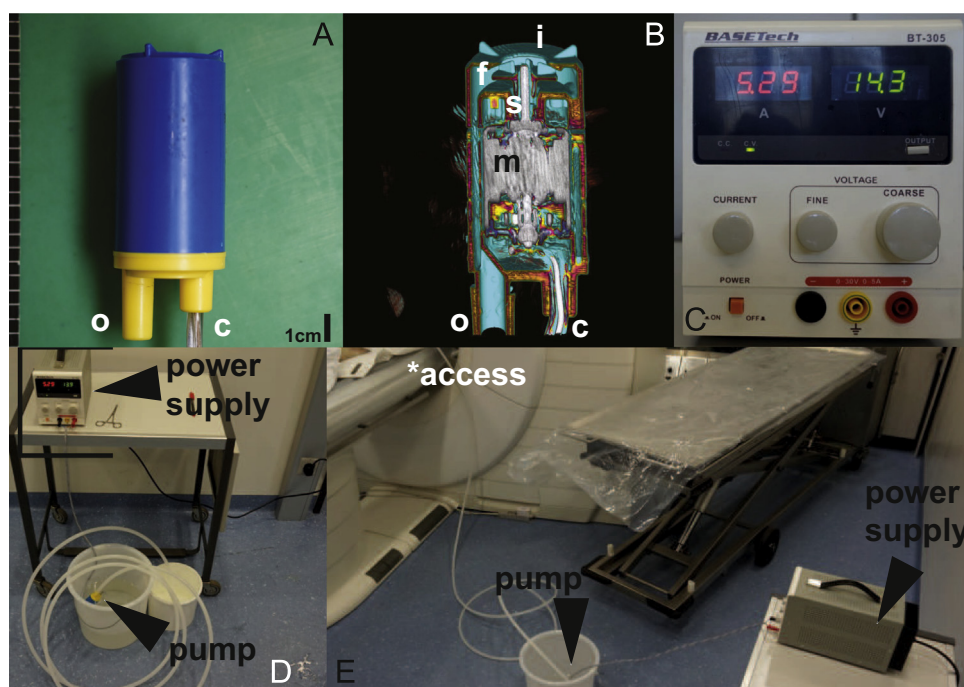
Immersion pump set up for usage in postmortem CT angiography. The pump (A, B: CT of the pump, view on front facing longitudinal virtual cut surface with inflow (i), outflow and conical tube connector (o), cable (c), motor (m), shaft (s) and paddle wheel (f)) is immersed in the contrast agent solution that we placed into a plastic container (shown in D and E). The pump draws electricity from a voltage controllable power supply (control panel in C; whole device in D, E). Display of the entire setup (E), a PVC tube connects the pump that is immersed inside the contrast agent container to the femoral region (*access) of the deceased positioned on the table of the postmortem CT.
